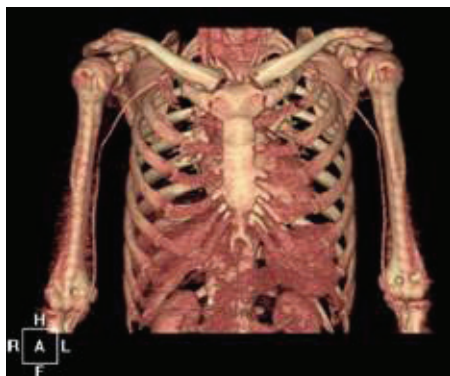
Follow-up upper-extremity computed tomography angiogram (three-dimensionally rendered). One month after cessation of ergotamine and nitroprusside infusion, both brachial arteries appeared normal.
